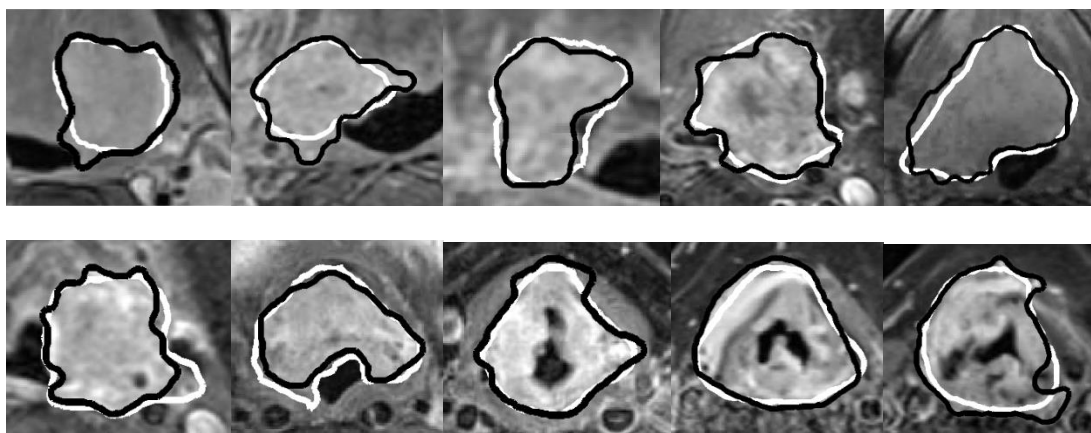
10 axial MRI slices from different patients demonstrating excellent agreement (DSC: >0.85) between C-auto (black outline) and C-gold (white outline) tumour outlines
